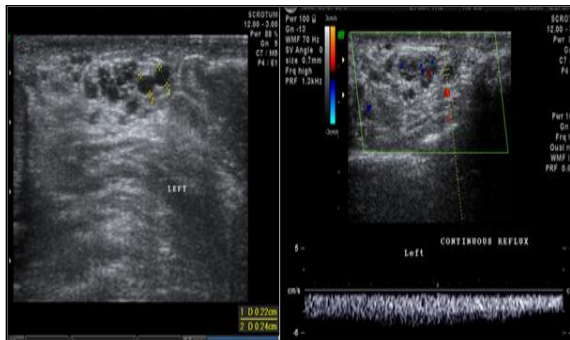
Infertile male patient of age 37 years, left sided dilated venous plexus (0.2) cm with continuous reflux on doppler study- Grade III
